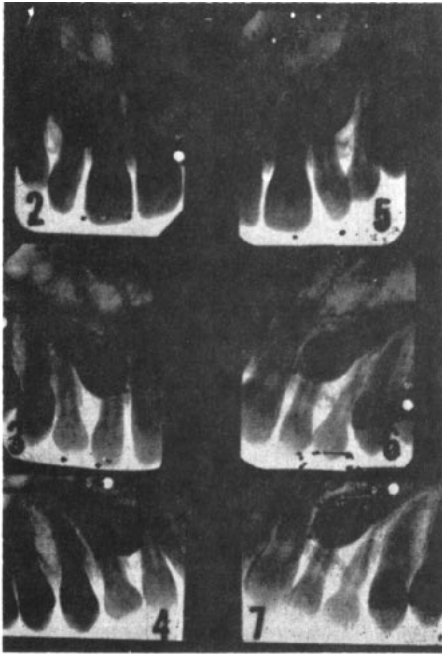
Localizing technic with three dental X-ray films demonstrating palatal position of right cuspid (No's. 2, 3 and 4) and labial position of left cuspid (No's. 5, 6 and 7.)
